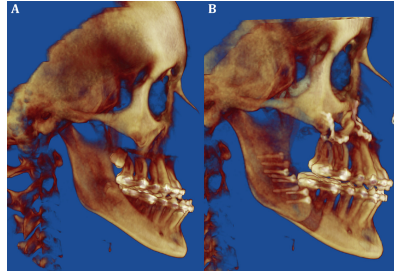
A patient with a Class III dentofacial deformities requiring orthognathic surgery. Pre-operative CBCT (A) and post-operative CBCT (B) are shown.
